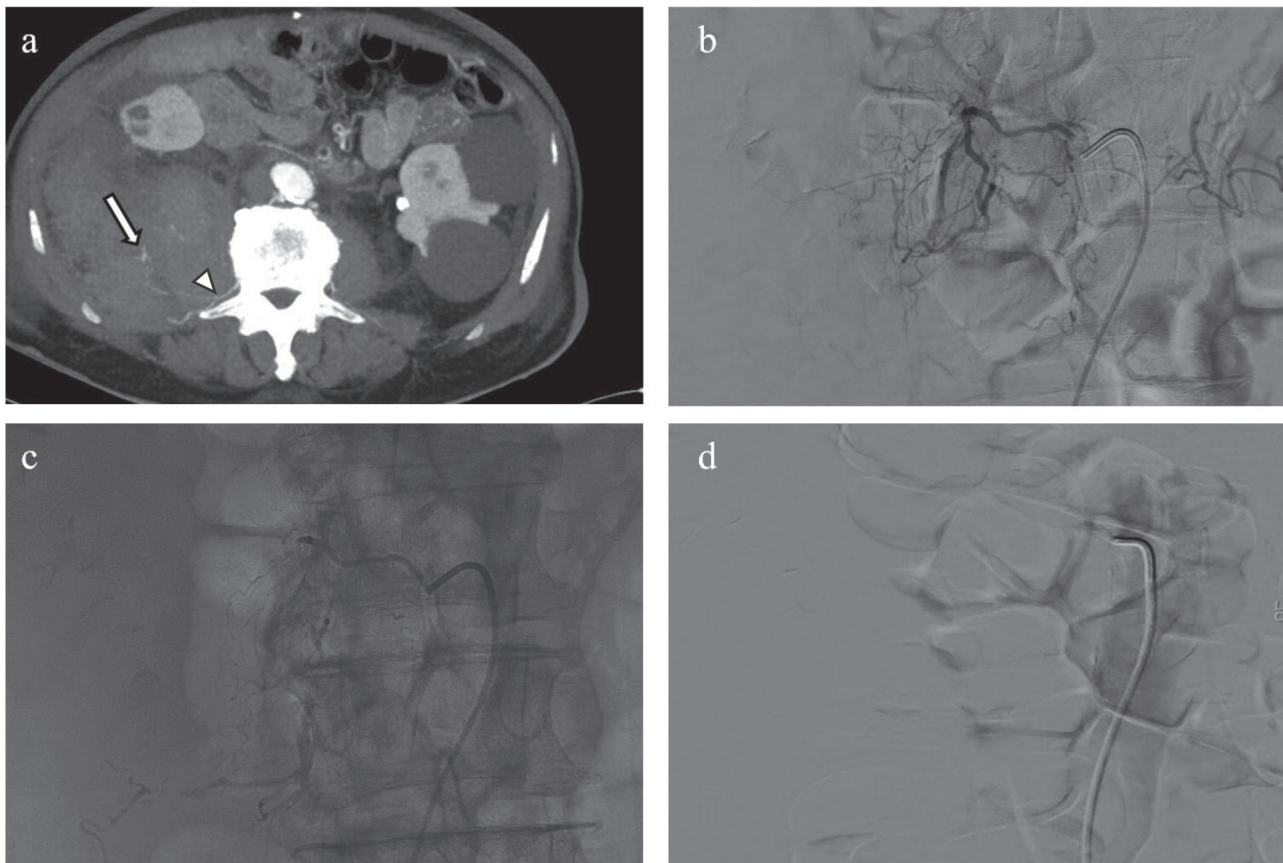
“Blind” embolization technique. (a) Pre-procedural axial arterial-phase CT MIP reconstruction image showing a large right iliopsoas hematoma with active arterial spots (arrow) refurnished by a (third lumbar spine vertebra (L3) level) right lumbar artery (arrowhead). (b) Selective DSA from a (L3 level) right lumbar artery without evidence of direct or indirect signs of bleeding. (c) Fluoroscopic image showing the blind embolization technique. Despite no evidence of active arterial blush, the lumbar artery was occluded with glue that formed multiple casts across the lumbar artery branches. (d) DSA after embolization of the (L3 level) right lumbar artery showing complete devascularization.
